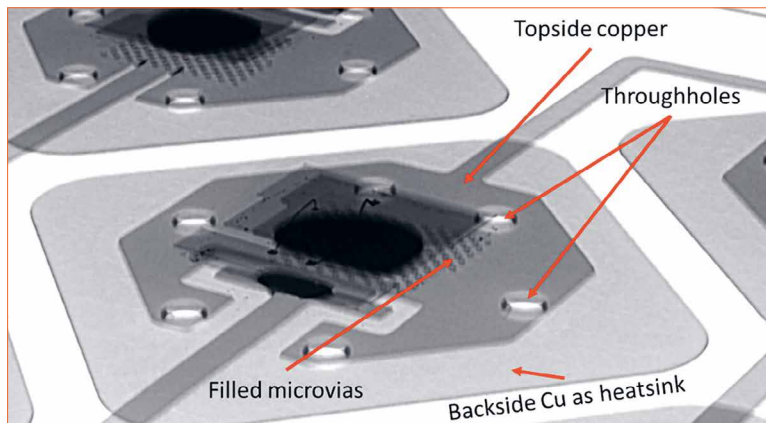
X-Ray image of a mounted LED
